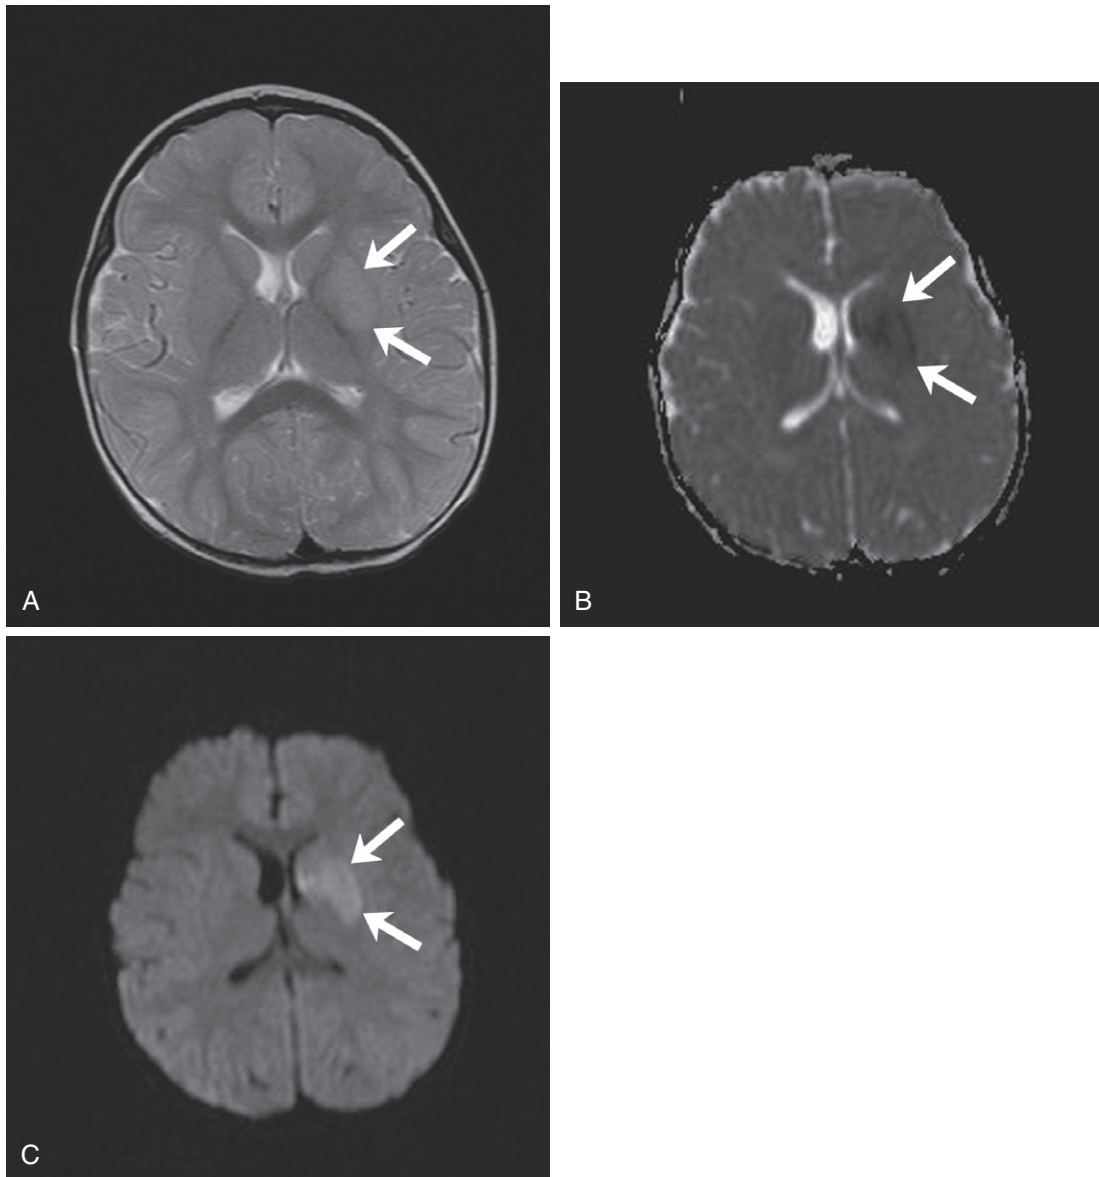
Basal ganglia acute infarct. Axial T2-weighted MR image (A) shows subtle increased T2 signal in left basal ganglia (arrows). More conspicuously shown on the apparent diffusion coefficient map (B) and diffusion-weighted images (C) is restricted diffusion (arrows) associated with an early infarct involving the left caudate and lentiform nuclei.
